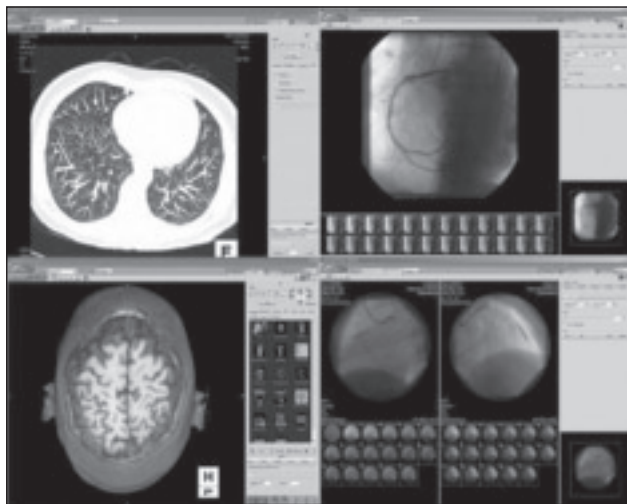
Images from various medical imaging modalities displayed on a thin-client software application. Angiography and biplane angiography (top and bottom right), pulmonary CT angiogram in axial maximum intensity projection (top left), and a volume-rendered representation of an MR image of the head (bottom left). (AquariusNET Client software image courtesy of TeraRecon, Inc.)
